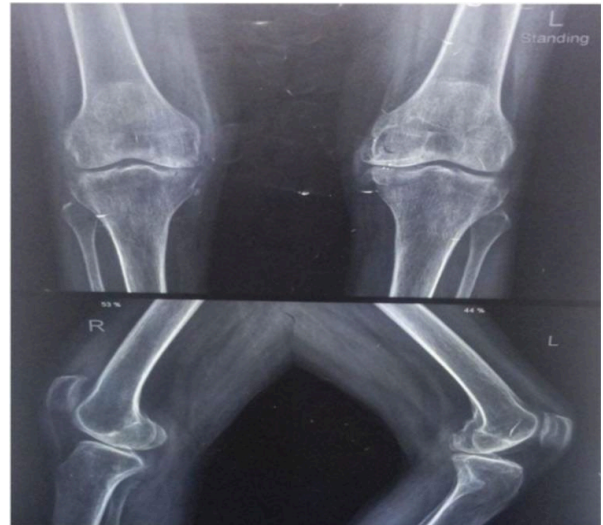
Pre-operative x-ray AP and lateral view of both knees
